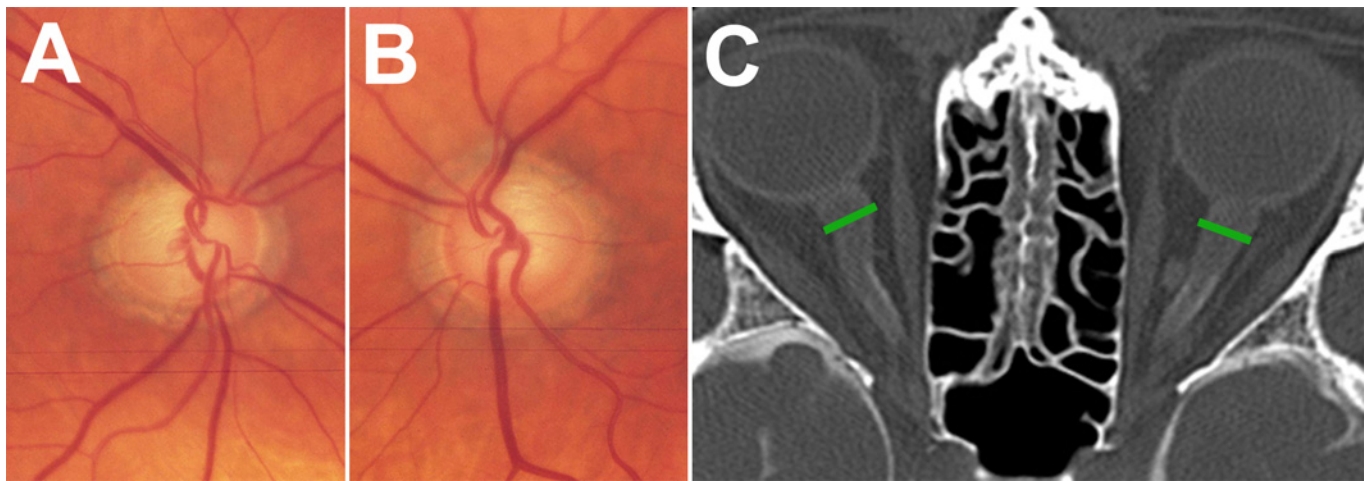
Optic disc of the right eye (A) and left eye (B) and CT cisternography (C) of patient number six, demonstrating impaired influx of contrast-loaded cerebrospinal fluid (CSF) into the anterior portion of the intraorbital subarachnoid space (SAS) of both optic nerves (ON). Note distention of both ON sheaths, most pronounced in the retrobulbar region. Widest optic nerve sheath diameter (ONSD): right 8.07 mm and left 8.17 mm (green bars).
